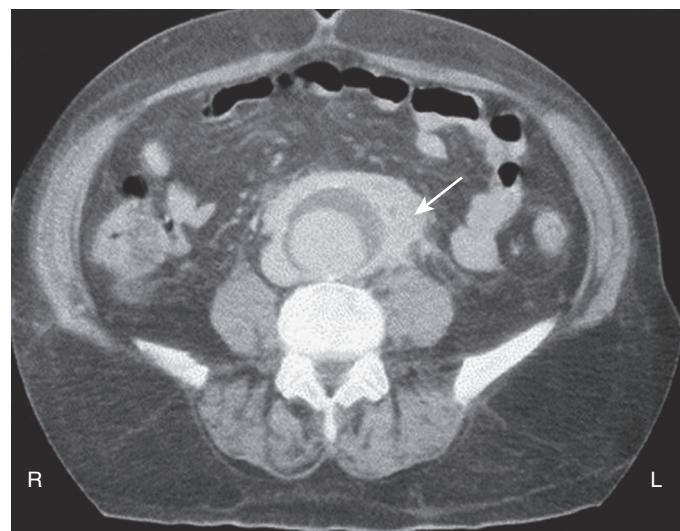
Typical appearance of inflammatory aortic aneurysm on computed tomography with thick periaortic fibrotic process. (From Speziale F, et al. Inflammatory aneurysms of the abdominal aorta involving the ureters: is combined treatment really necessary? *J Urol*. 2001;165:27–31.)
